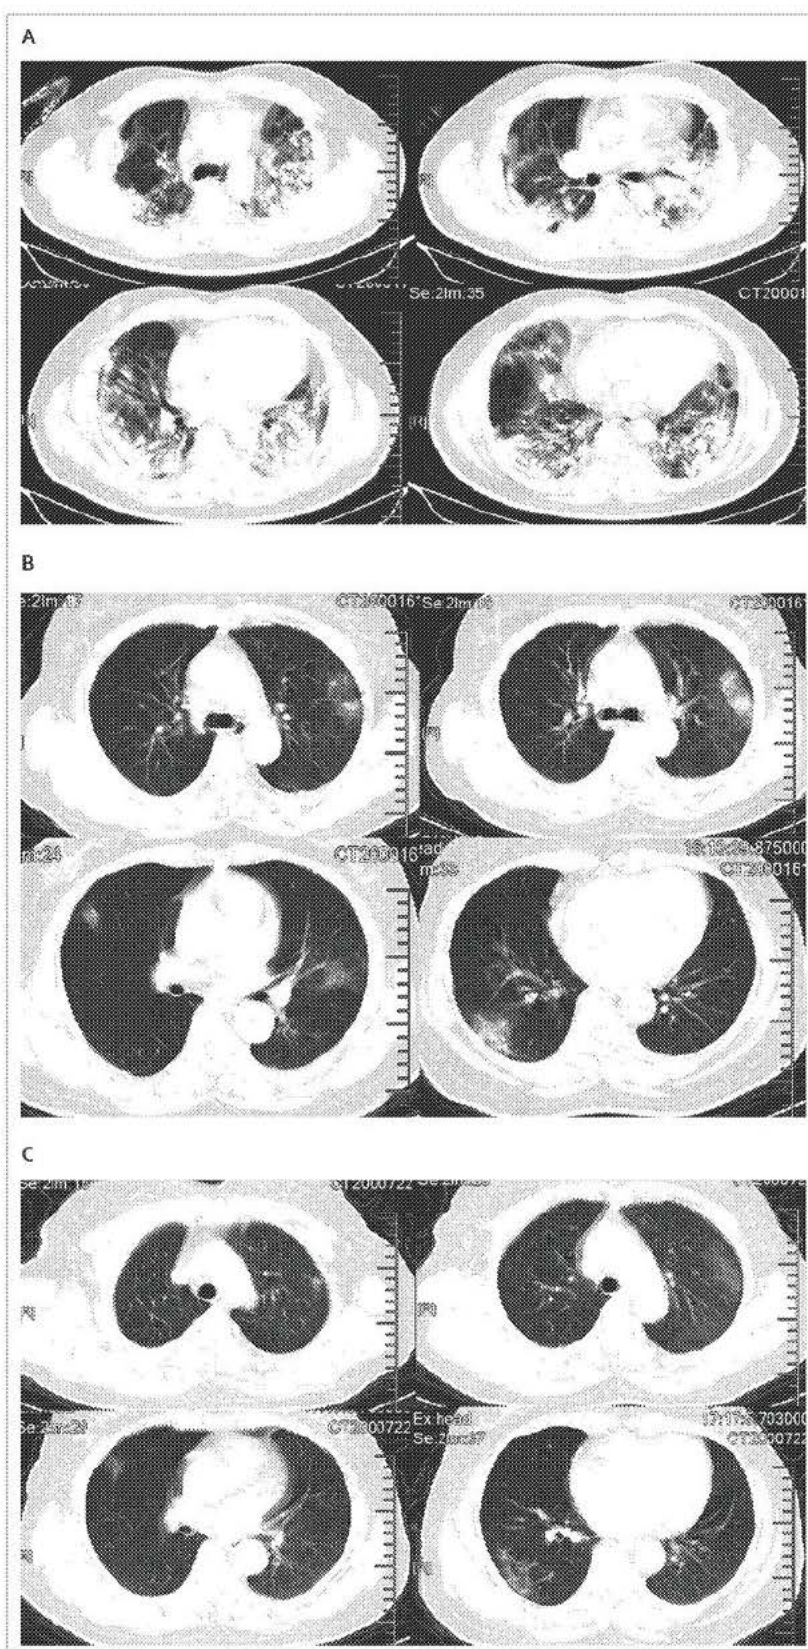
Chest CT images
